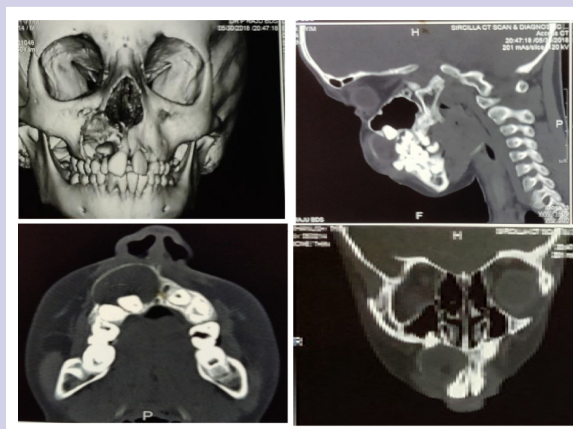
CT scan of Head and Neck showing well defined cyst.
